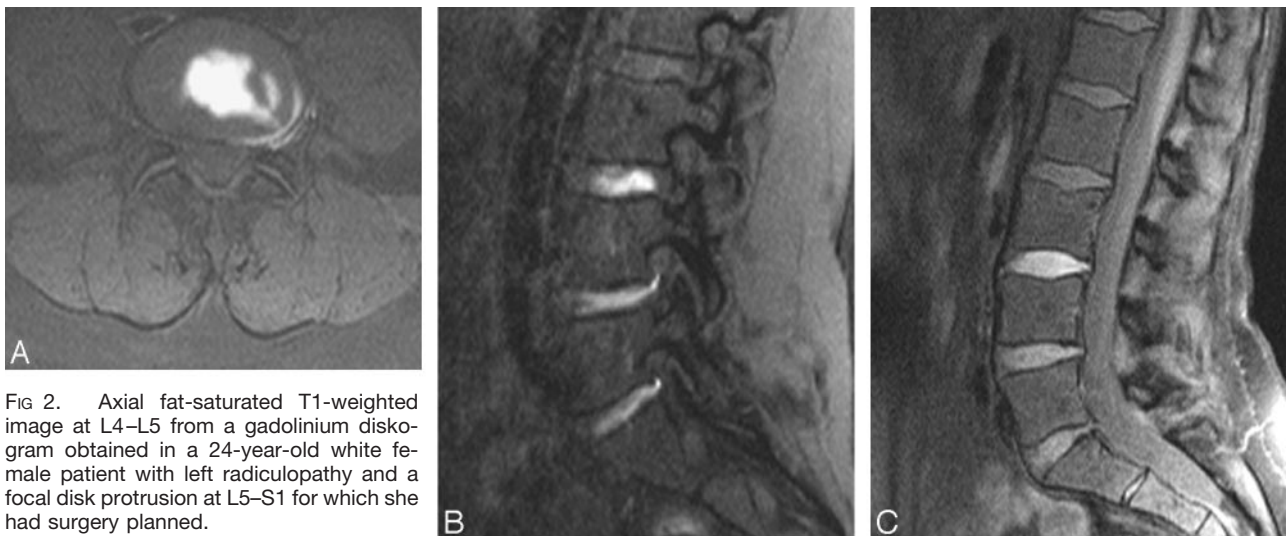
Axial fat-saturated T1-weighted image at L4-L5 from a gadolinium diskogram obtained in a 24-year-old white female patient with left radiculopathy and a focal disk protrusion at L5-S1 for which she had surgery planned.
